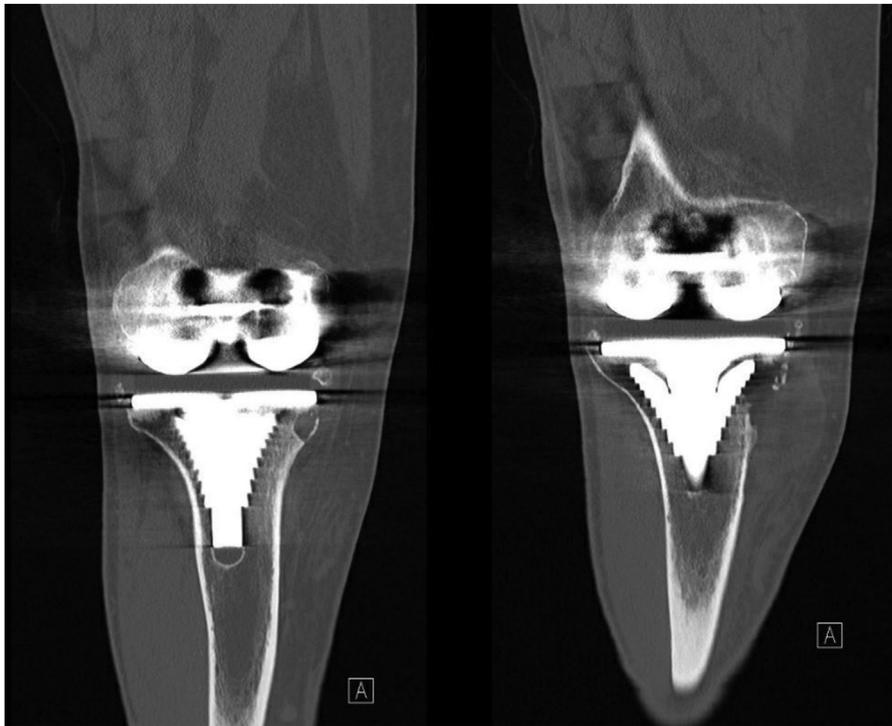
Computed tomography (CT) scan of right revision TKA with Sigma PFC TC3 revision knee system with medial tibial plateau erosions adjacent to the associated soft tissue mass at the medial tibial plateau.
